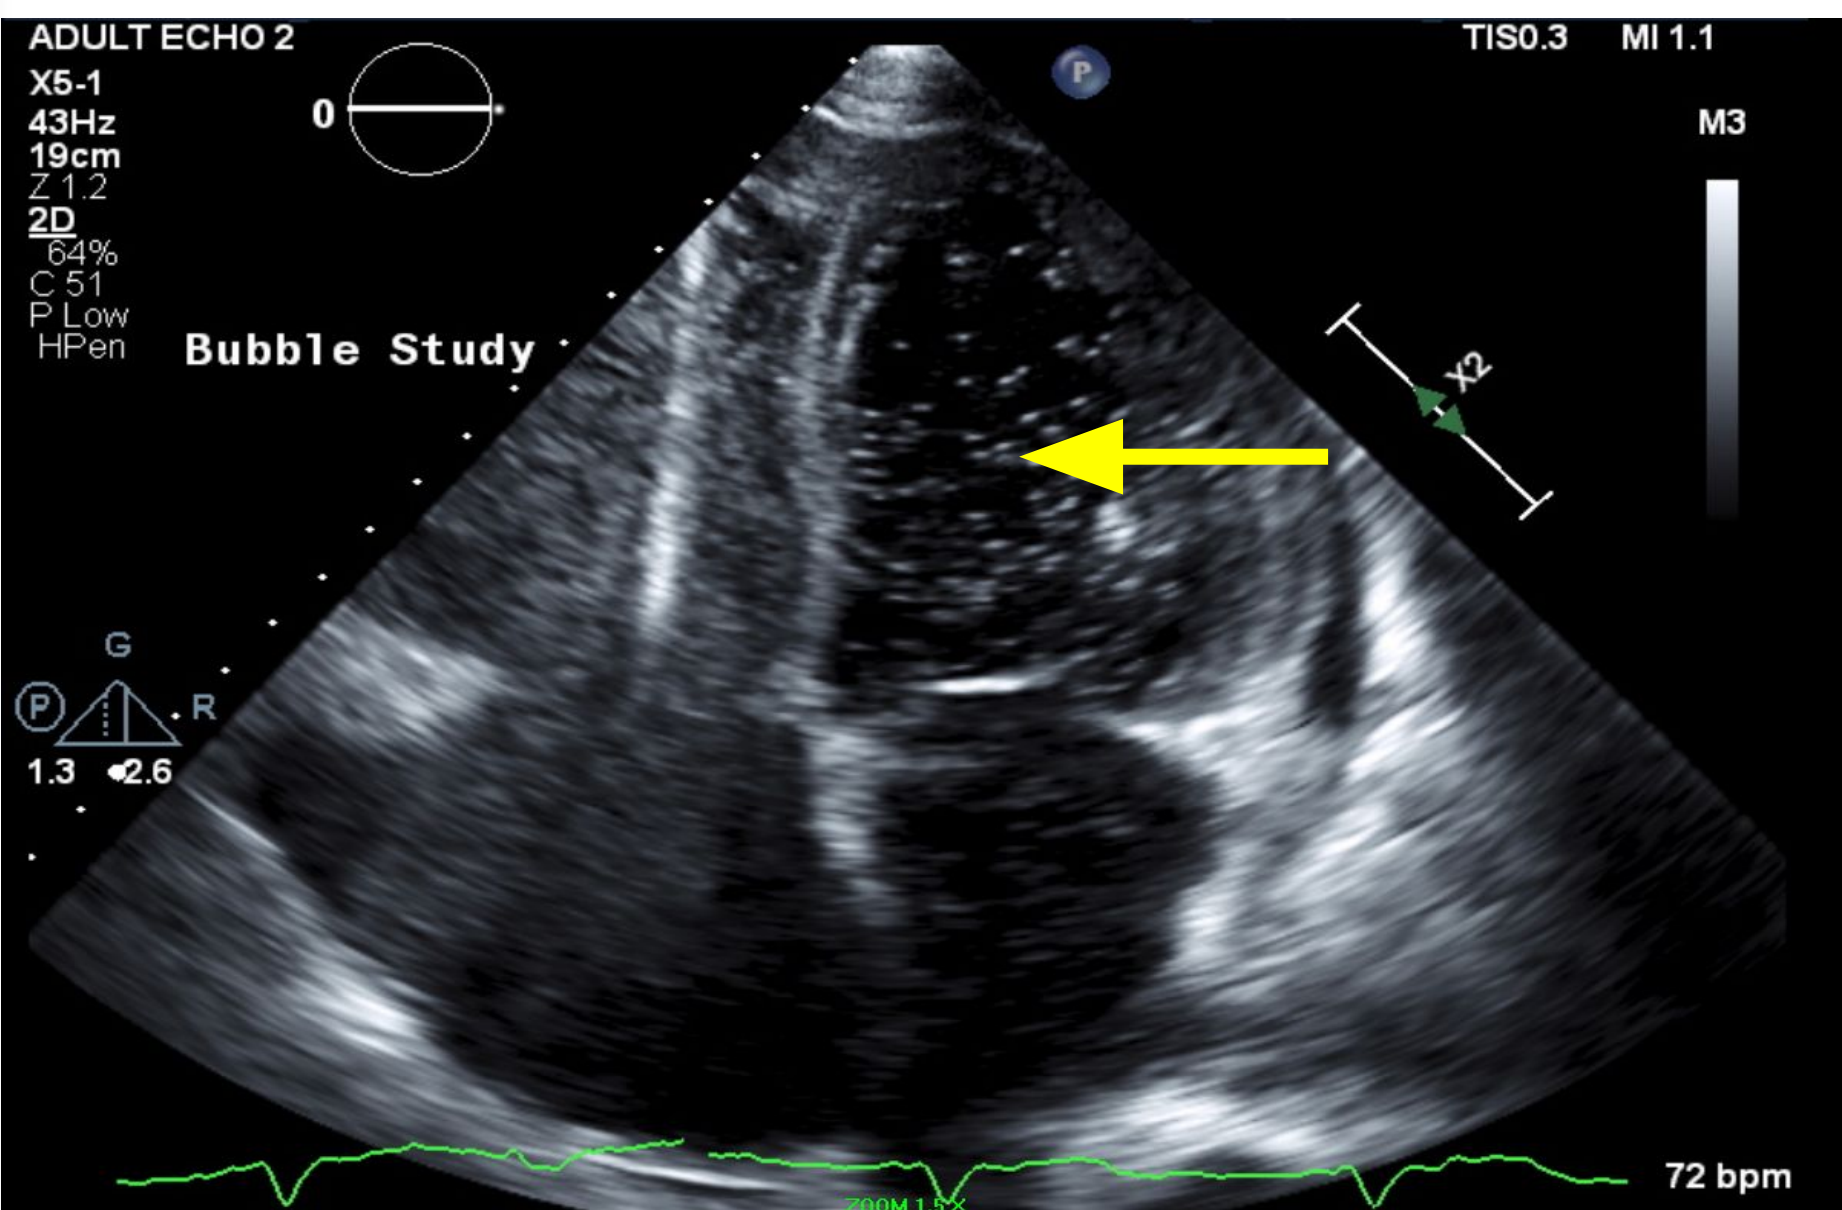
Echocardiogram: apical four chamber view with bubble study shows bubbles in the second ventricular beat.
